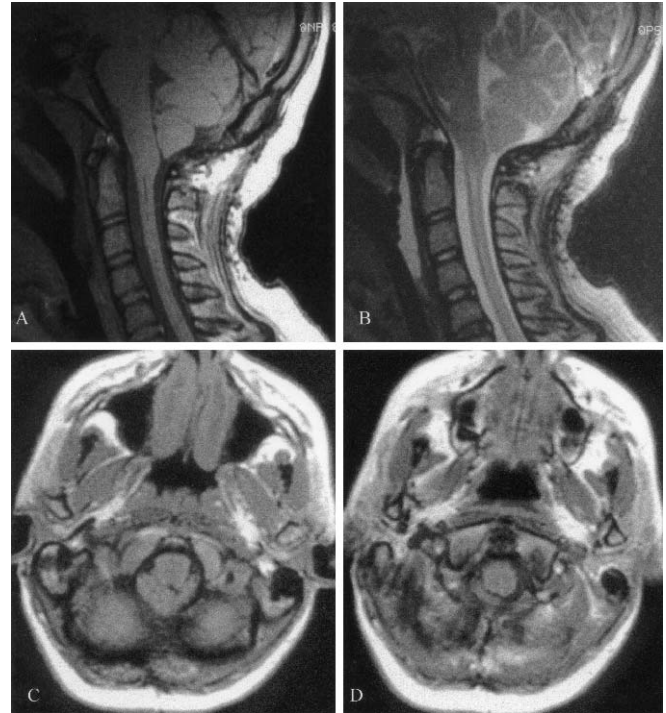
MRI of a 10-year-old girl presenting with cervico-nuchal pain. Midsagittal A T1-weighted and B T2-weighted images, and C, D axial T1-weighted images at the foramen magnum—C1 level. The cerebellar tonsils are mildly displaced into the cervical canal and their inferior aspect is pointed; the subarachnoid spaces at the foramen magnum are still present, though reduced in size. A mild increase in the size of the central canal is better appreciated on T2-weighted images (B)
